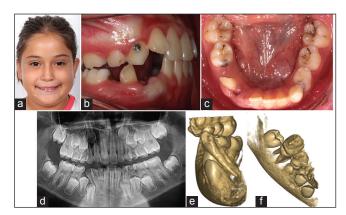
(a-f) Extra-oral/intraoral photographs and radiographs of the patient before orthodontic treatment
